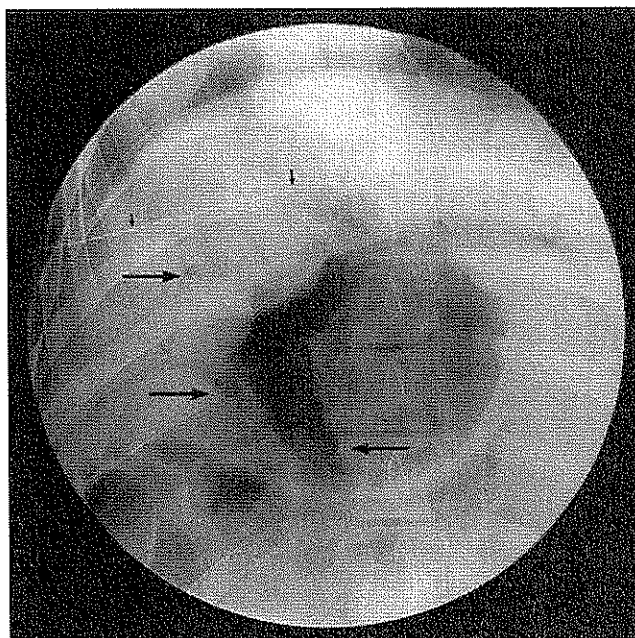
Plain film of intraparenchymal CO₂ portal venography shows that the tip of fine needle is percutaneously placed at the left medial lobe of liver (*small arrows*). The portal tree is also visualized (*long arrows*)
